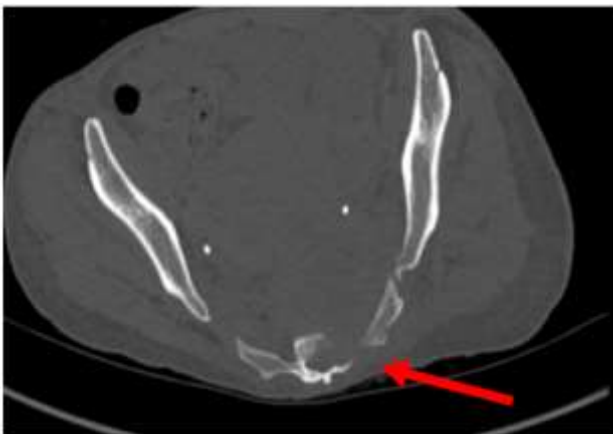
CT axial slice in bone windowing demonstrating sacral lysis from tumour invasion (red arrow).
